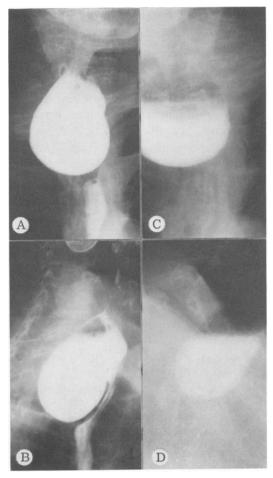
Esophageal roentgenograms in patient with large pharyngo-esophageal diverticulum. A and B, Before operation. C and D, Fourteen months later.
